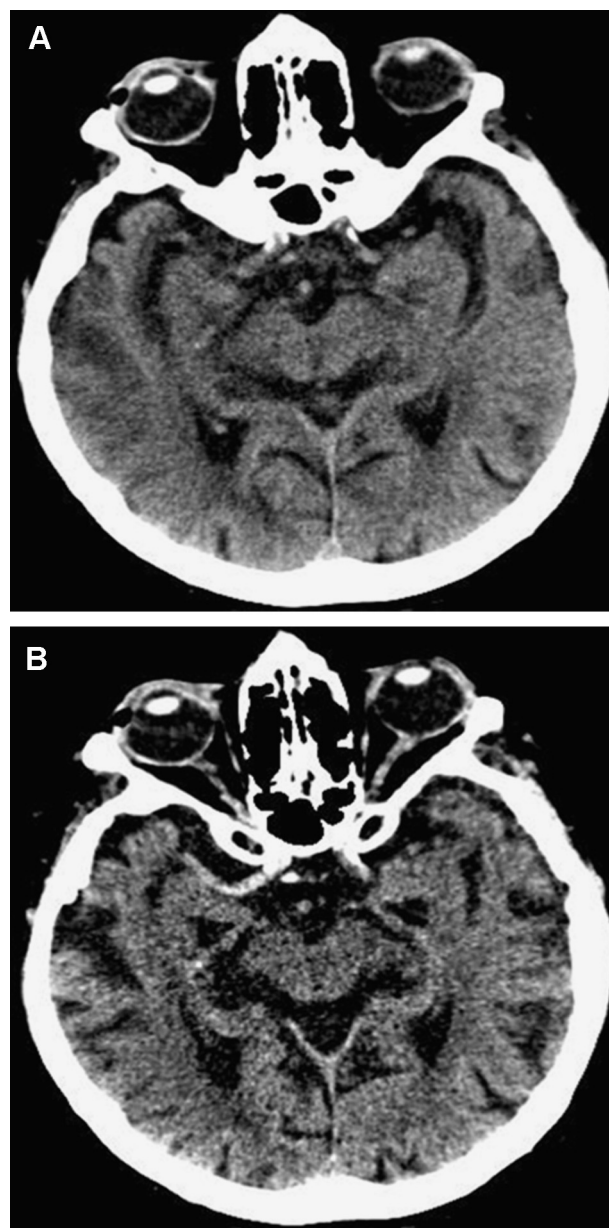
A. Unenhanced CT with 6 mm slice thickness of 78 years old woman with left-sided hemiparesis since 2 hours. B. A 1.5 mm slice of the CT in Fig. 1A showing thrombo-embolic occlusion of right middle cerebral artery trunk.
